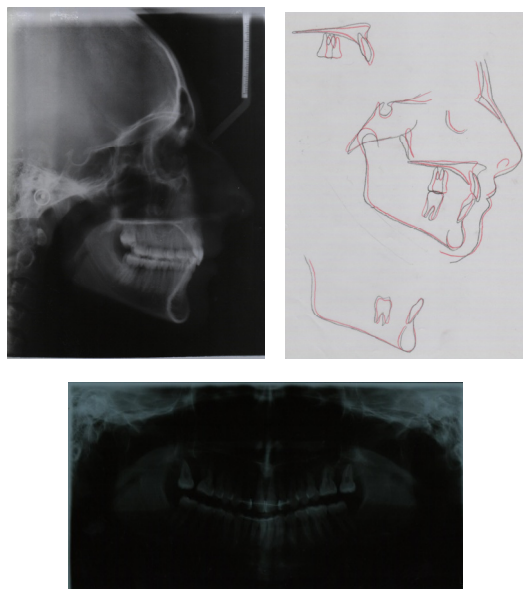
figs 12-a to 12-c, post treatment cephalogram, superimposition of pretreatment (red) and post treatment (black) cephalometric tracings, and panoramic radiograph.
